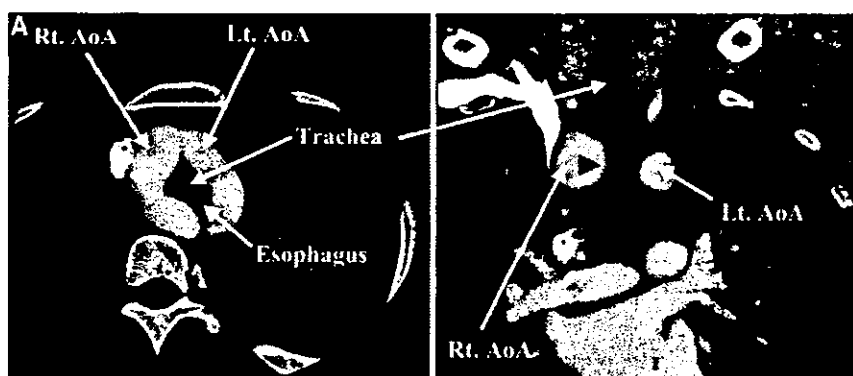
Axial source image (A) and multiplanar reconstruction image from the coronal view (B) of enhanced multislice CT revealed separate right (rt.) and left (lt.) aortic arches (AoA). The trachea and esophagus were surrounded by a vascular ring made by the double AoA (A), and the trachea was actually slightly compressed by the vascular ring (B, arrowheads).
